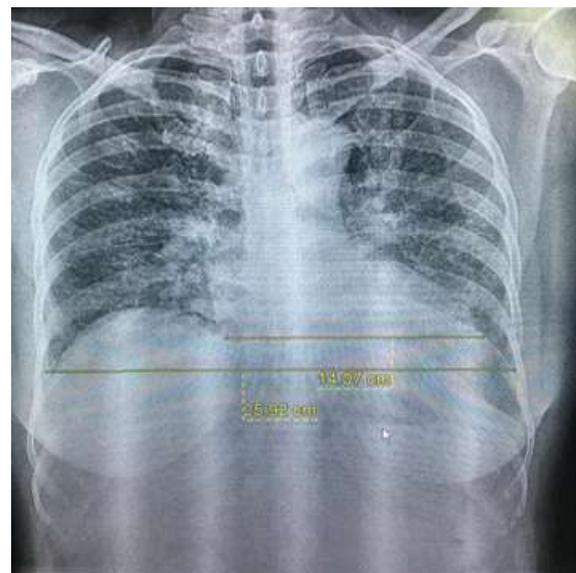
Chest X-Ray PA view showing Cardiomegaly
